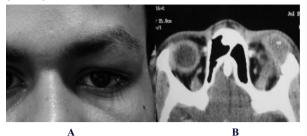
(a) Periocular (non-eyelid) mass with inferiorly displaced globe (left side) on clinical presentation and (b) CT scan-coronal section showing cold abscess with lateral and superior wall bony erosion in left orbit.
